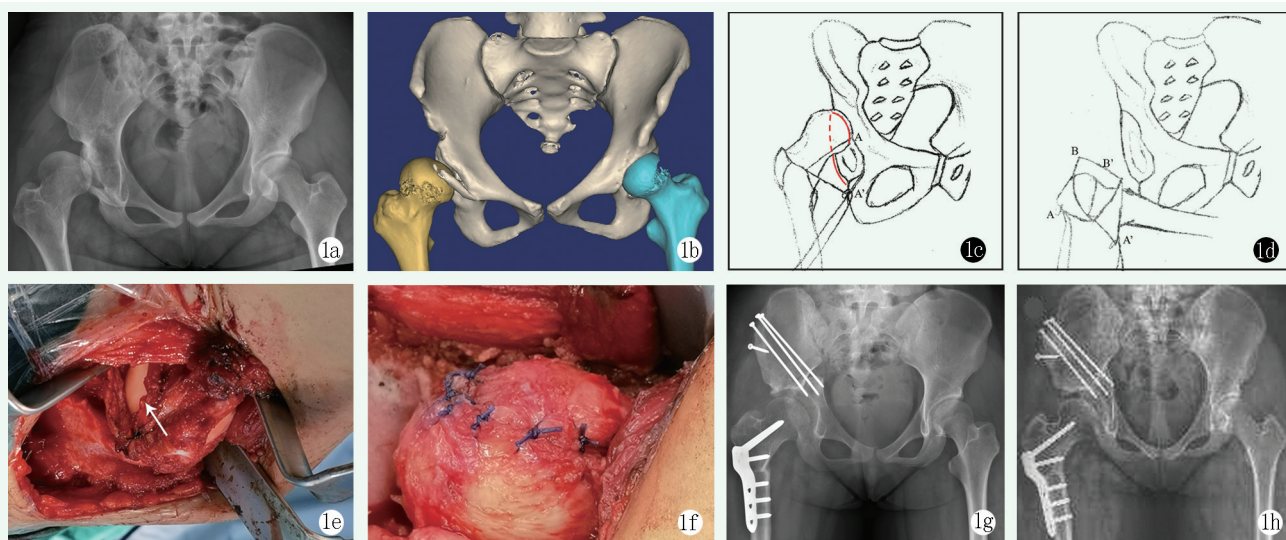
患儿女性，13 岁 9 个月。1a：术前 X 线片示右侧 CDH 术后再脱位，髋臼发育差，股骨头无明显骨性覆盖；1b：应用 3D CT 模拟股骨头复位并获得足够包容 (CEA=25°)，此时股骨头已突破髋臼内壁，提示单纯关节囊成形术无法获得足够包容；1c：自髋臼缘切开发节囊，屈髋内收外旋使股骨头远离髋臼；1d：修剪关节囊并包裹股骨头，适度扩臼；1e：术中先行缝合内侧关节囊以覆盖头臼交界处；1f：后缝合前外侧关节囊；1g：联合应用关节囊成形术和 Chiari 截骨术，术后头臼匹配，骨性覆盖充分；1h：术后 2 年 X 线片示右髋关节包容良好，未发生缺血性坏死。
